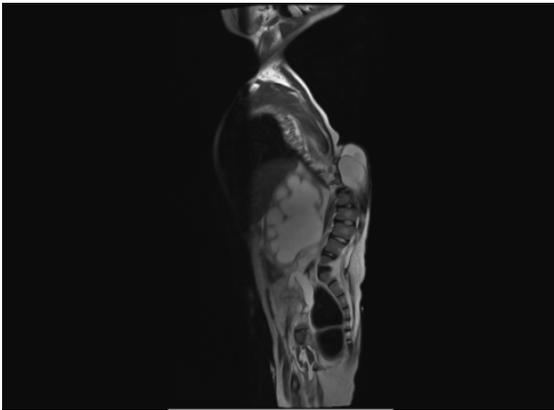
S Ionut's MRI: neuropathic bladder and bilateral ureterohydronephrosis.
